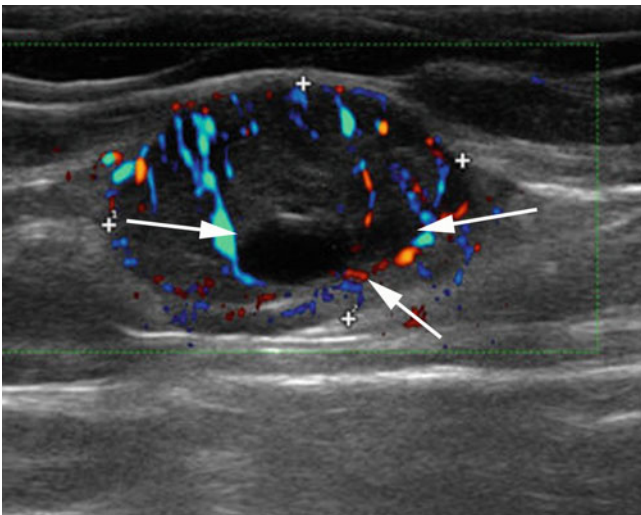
Metastatic lymph node. Directional power Doppler image. Balloon-shaped, 24 × 16 mm lymph node with totally vanished central hilum and irregular perfusion. Note the area without any vascularization (*arrows* – necrotic area?) and the overall three-dimensional impression
